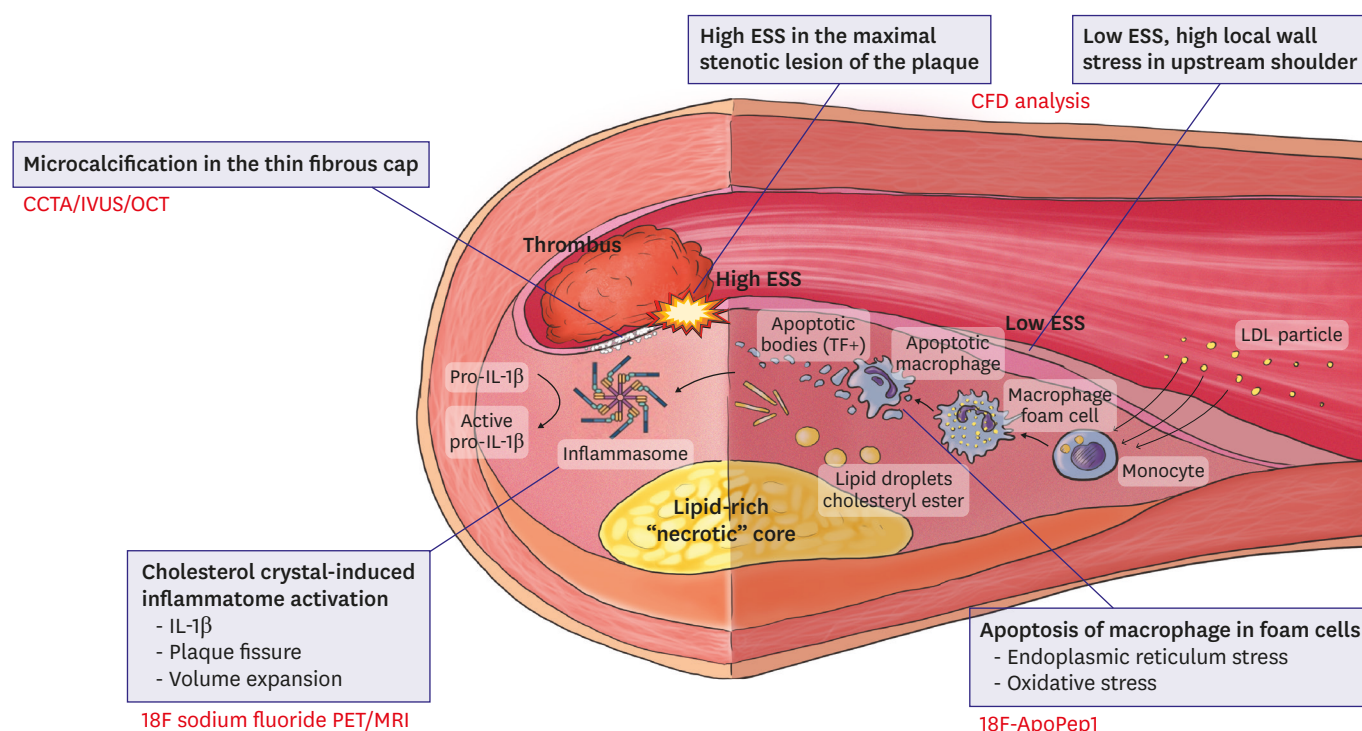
Newly added pathophysiological concept of vulnerable plaques and the applicable imaging modalities to detect the process of plaque rupture. CCTA = coronary computed tomography angiography; CFD = computational fluid dynamics; ESS = endothelial shear stress; IL = interleukin; IVUS = intravascular ultrasonography; LDL = low-density lipoprotein; MRI = magnetic resonance imaging; OCT = optical coherence tomography; PET = positron emission tomography.
